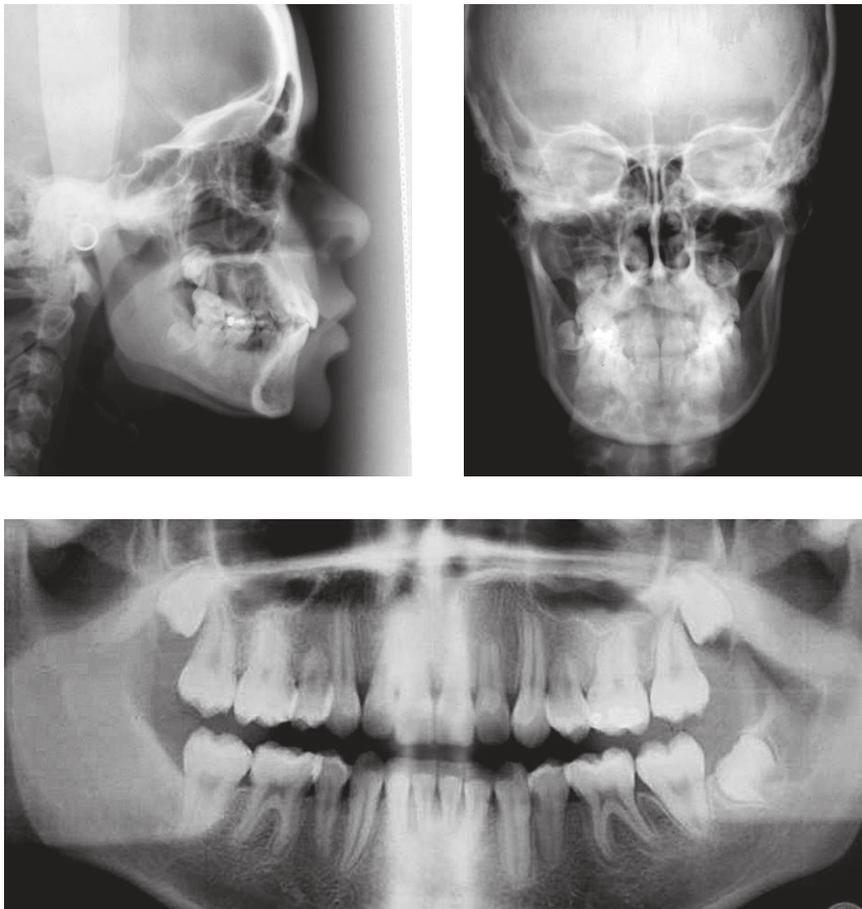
Final radiographs: lateral teleroadiograph, frontal teleroadiograph and panoramic radiograph.
